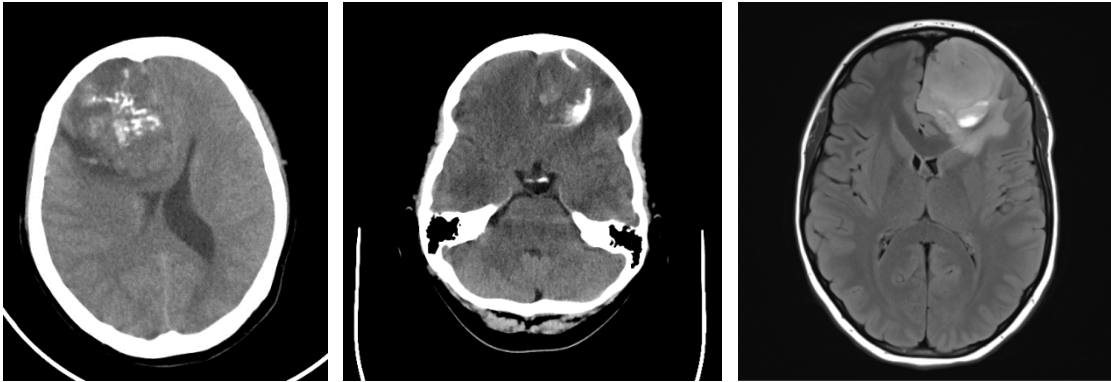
CT and MRI scans of oligodendrogliomas are shown. The left (27) and middle (28) CT scan show calcifications, the MRI (right) shows moderate mass effect (28).
